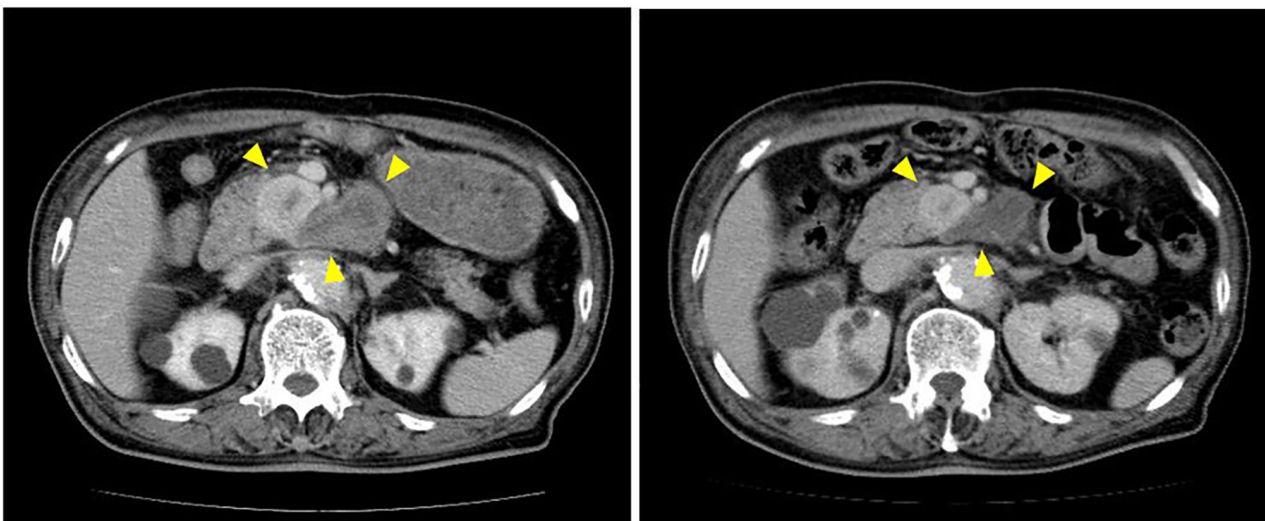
Tumor response. Contrast-enhanced computed tomography revealed that the tumor shrank to 7.3 cm in diameter 3 months after treatment (left) and showed maintenance of partial response after 24 months of treatment (right). Arrowheads indicate the tumor.
